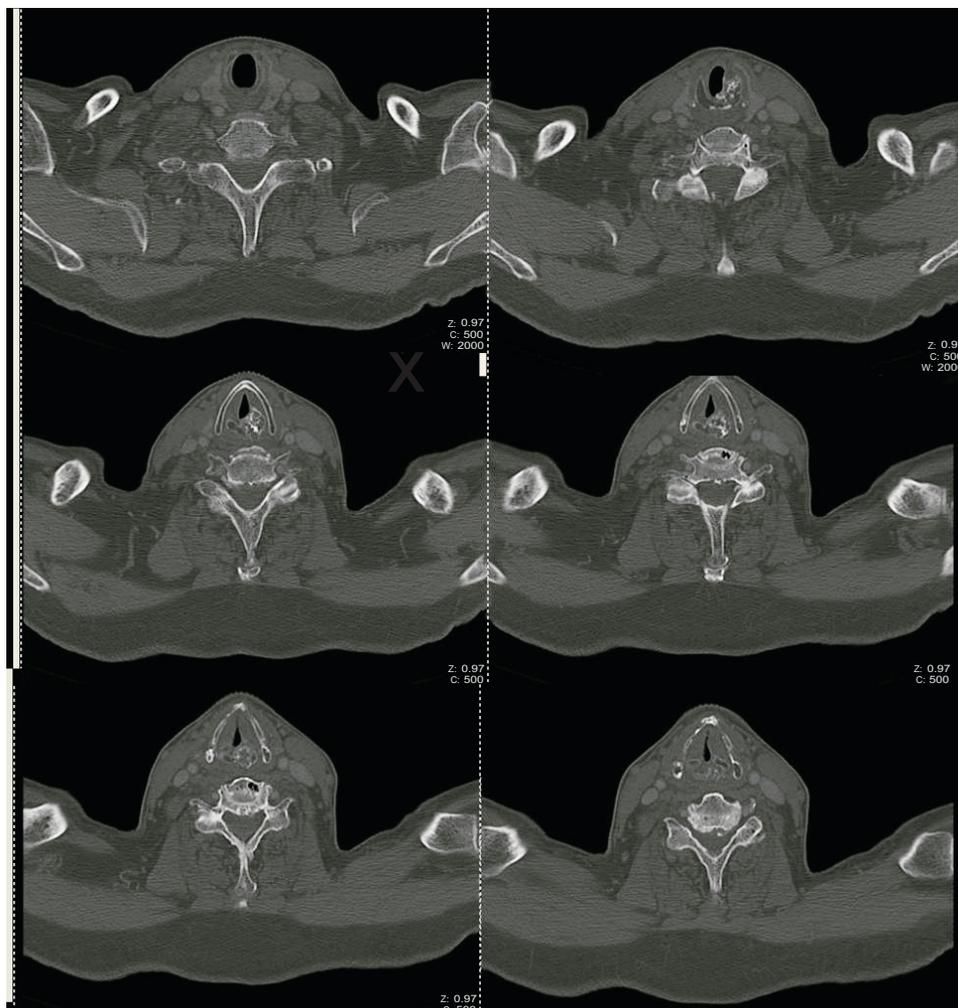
Neck computed tomography, following endoscopic removal of tumor and radiation treatment. There is marked decrease in size of the laryngeal mass with residual calcifications, which have remained stable to date.
